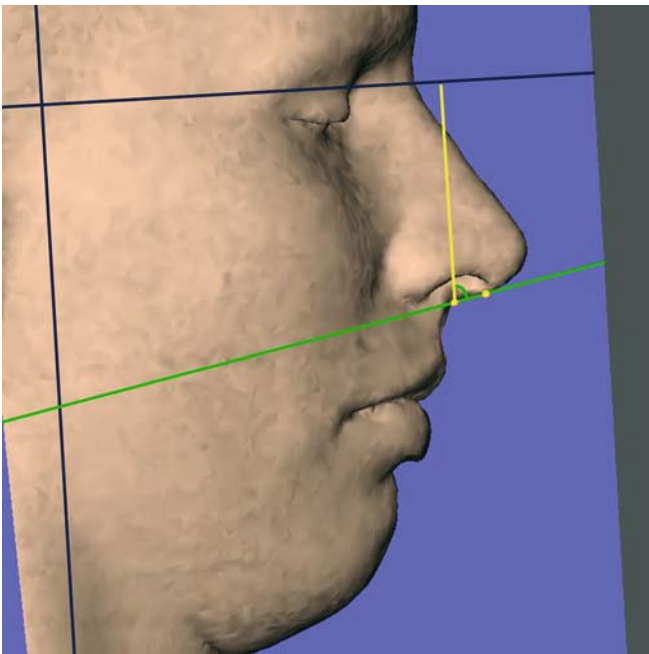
The inclination of the columella from the vertical plane, $sn-c''$ / y -plane, is a projected angular soft tissue measurement on the median (z) 3-D cephalometric reference plane (3-D CT, soft tissues, patient K.C.)
